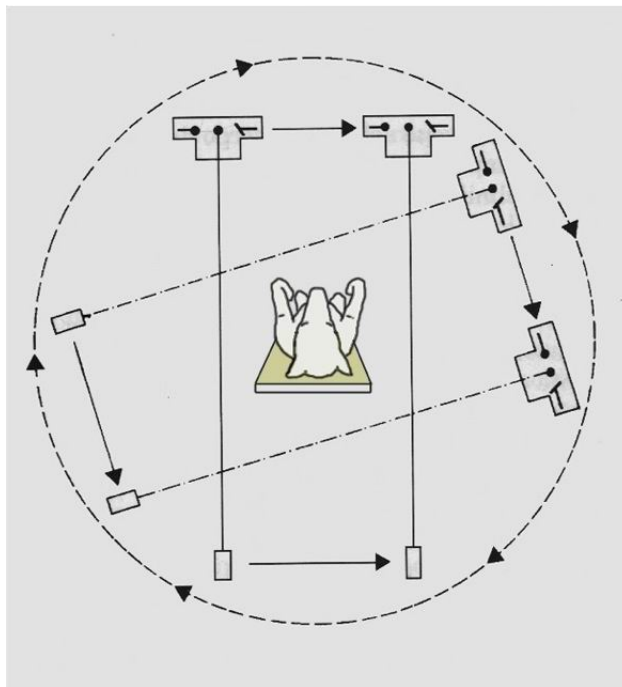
A representation of first generation CT scanner (Parallel Beam, Translate-Rotate).
